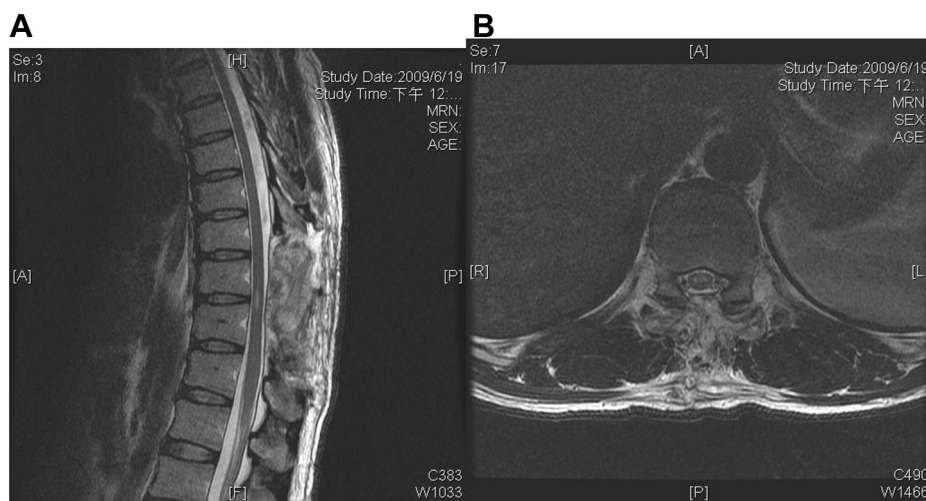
T2-weighted sagittal magnetic resonance imaging after laminectomy and removal of the hematoma: (A) sagittal view; (B) transverse view.
